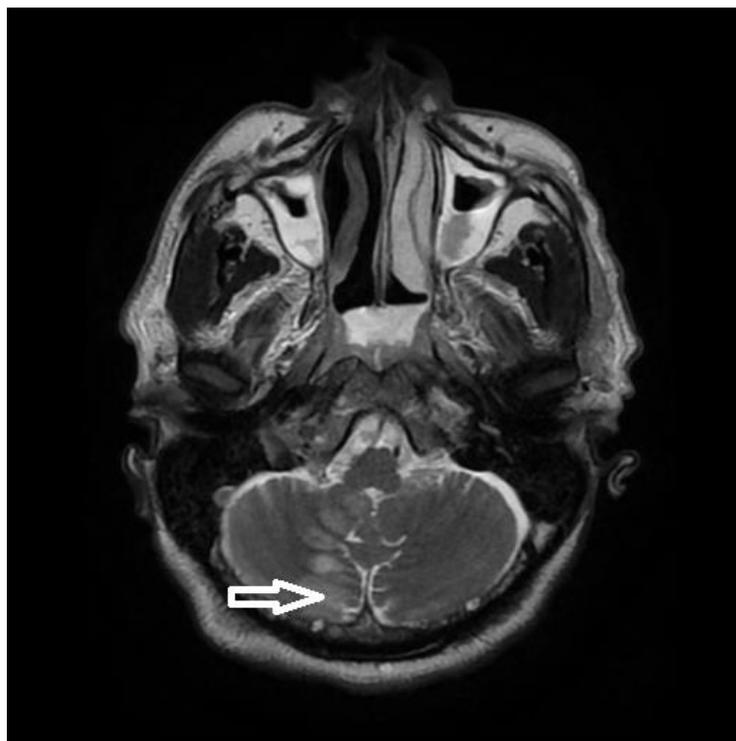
Brain MRI showing hypodensity lesion in left cerebral hemisphere (arrow).
